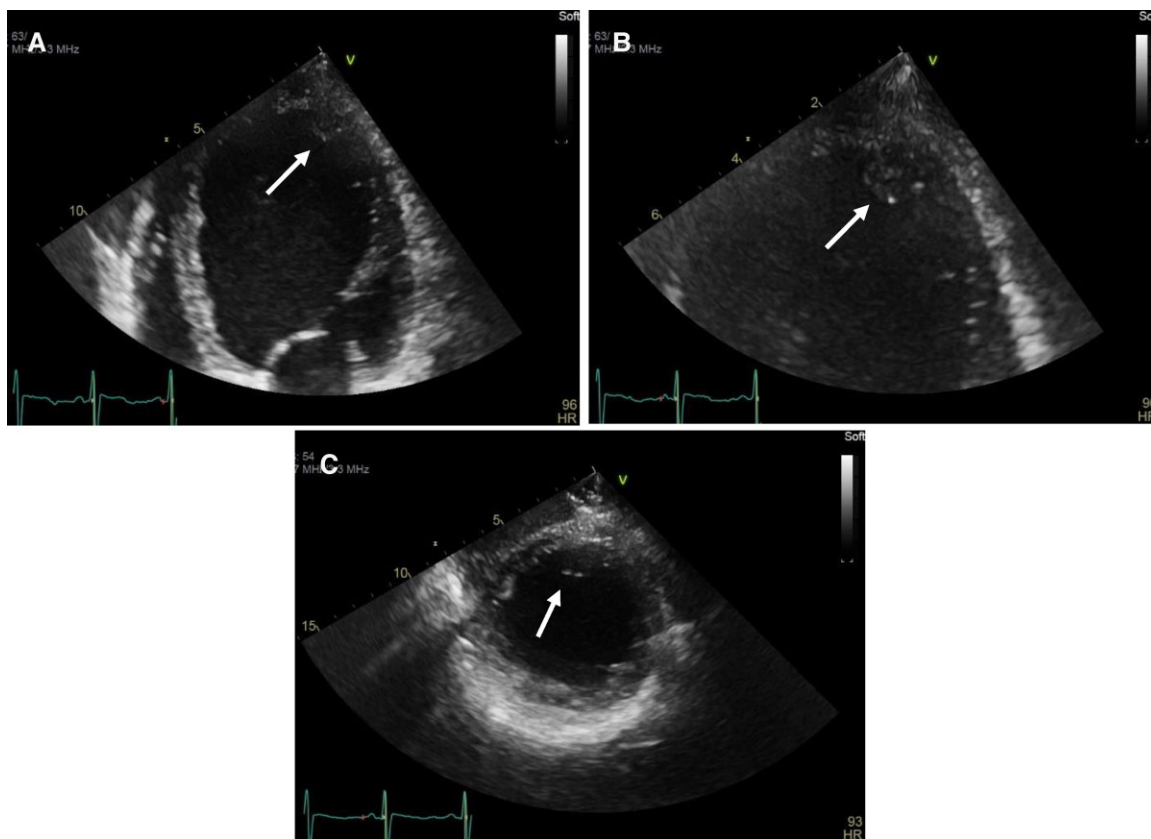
Transthoracic echocardiography images following the STEMI raised the suspicion of apical LV thrombus. (A,B) Apical 4-chamber view, (C) Parasternal short-axis view.
